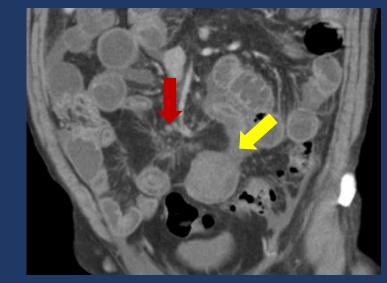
Coronal CT image showing a intraluminal soft tissue lesion (yellow arrow) with retractile desmoplastic fibrosis in adjacent mesentery (red arrow).
